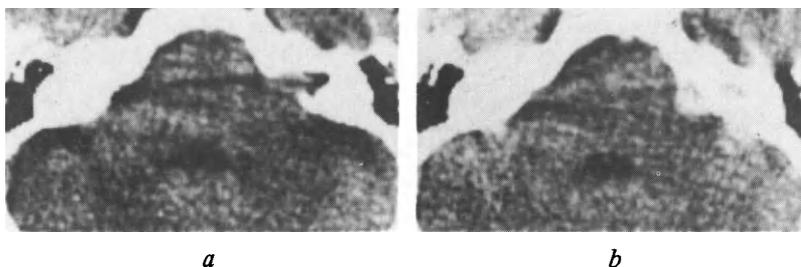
Acoustic neurinoma. *a*, Plain CT: widened internal auditory meatus. *b*, With intravenous contrast medium: enhanced mass in the right cerebello-pontine angle and within the internal auditory meatus. The tumour is isodense with brain and not clearly identified on the plain scan. Removed at surgery, it was 7.5 mm in diameter.
